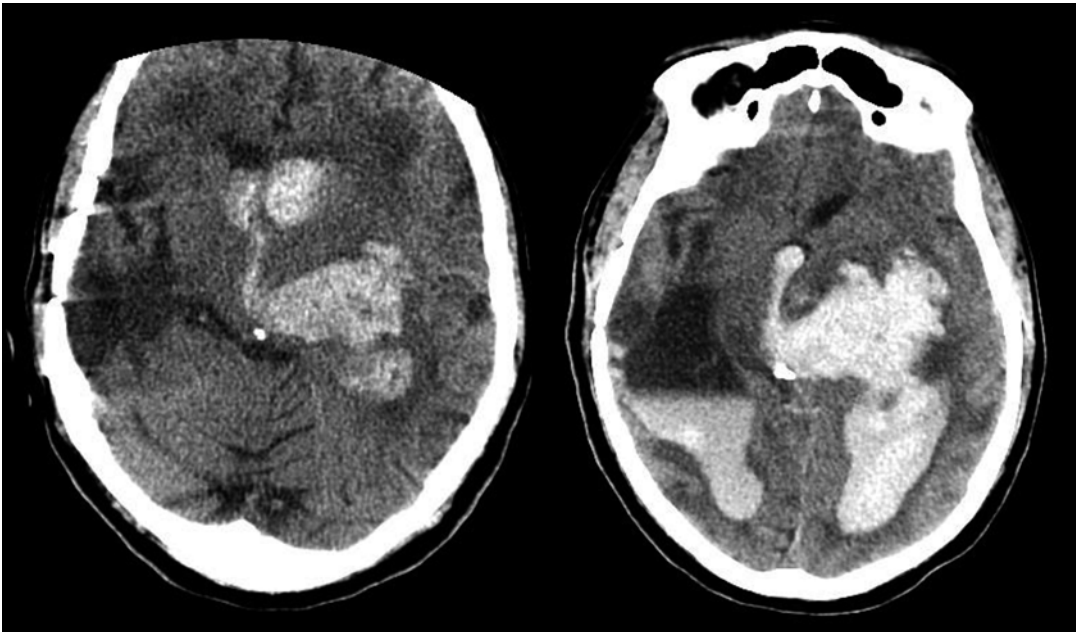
Non-contrast CT demonstrating basal ganglia ICH with intraventricular extension (*left*) in patient with INR of 1.7. Repeat non-contrast CT (*right*) showing
